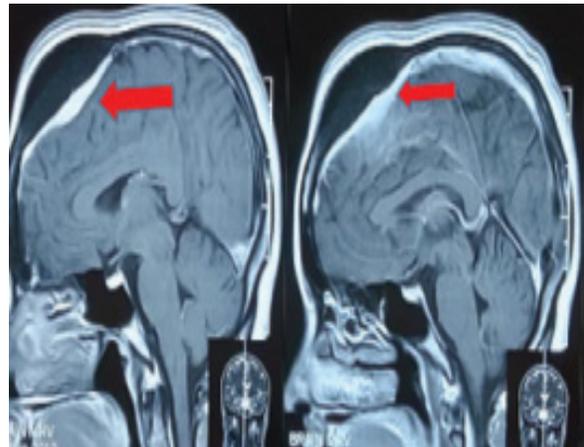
Magnetic resonance imaging T1W post-contrast sagittal images showing enhancement of inner part of the lesion and adjacent meninges
